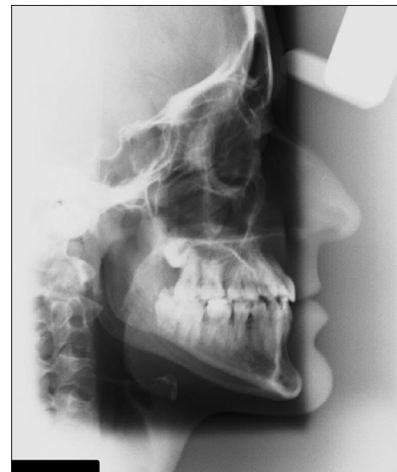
Posttreatment cephalogram radiograph
